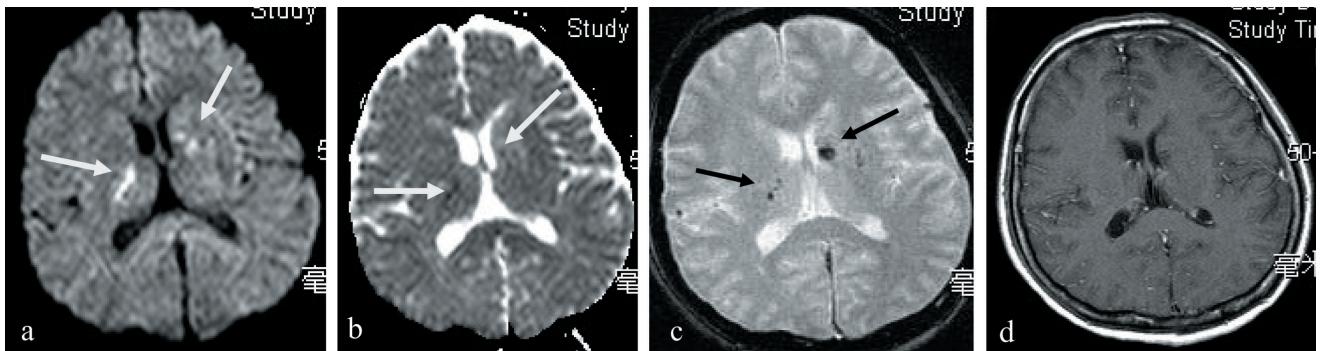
Findings of brain magnetic resonance imaging study (June 3rd, 2008). (a) Diffusion-weighted image shows hyperintensities at the right internal capsule (arrow) and left caudate nucleus (arrow); (b) Apparent diffusion coefficient map shows hypointensities at the right internal capsule (arrow) and left caudate nucleus (arrow); (c) Gradient echo sequence reveals decreased signals at left caudate nucleus and right internal capsule (arrow); (d) Negative finding in gadolinium contrast-enhanced T1-weighted image
